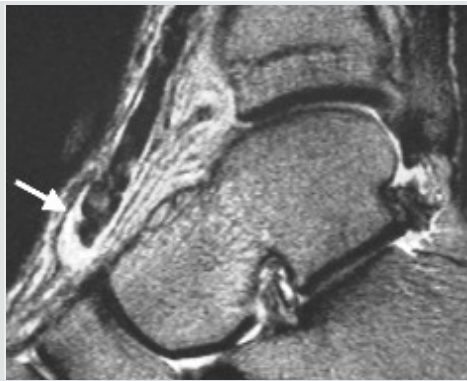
Magnetic resonance imaging scan of the patient's ankle joint. The proximal stub of the anterior tibial tendon can be seen (white arrow).
